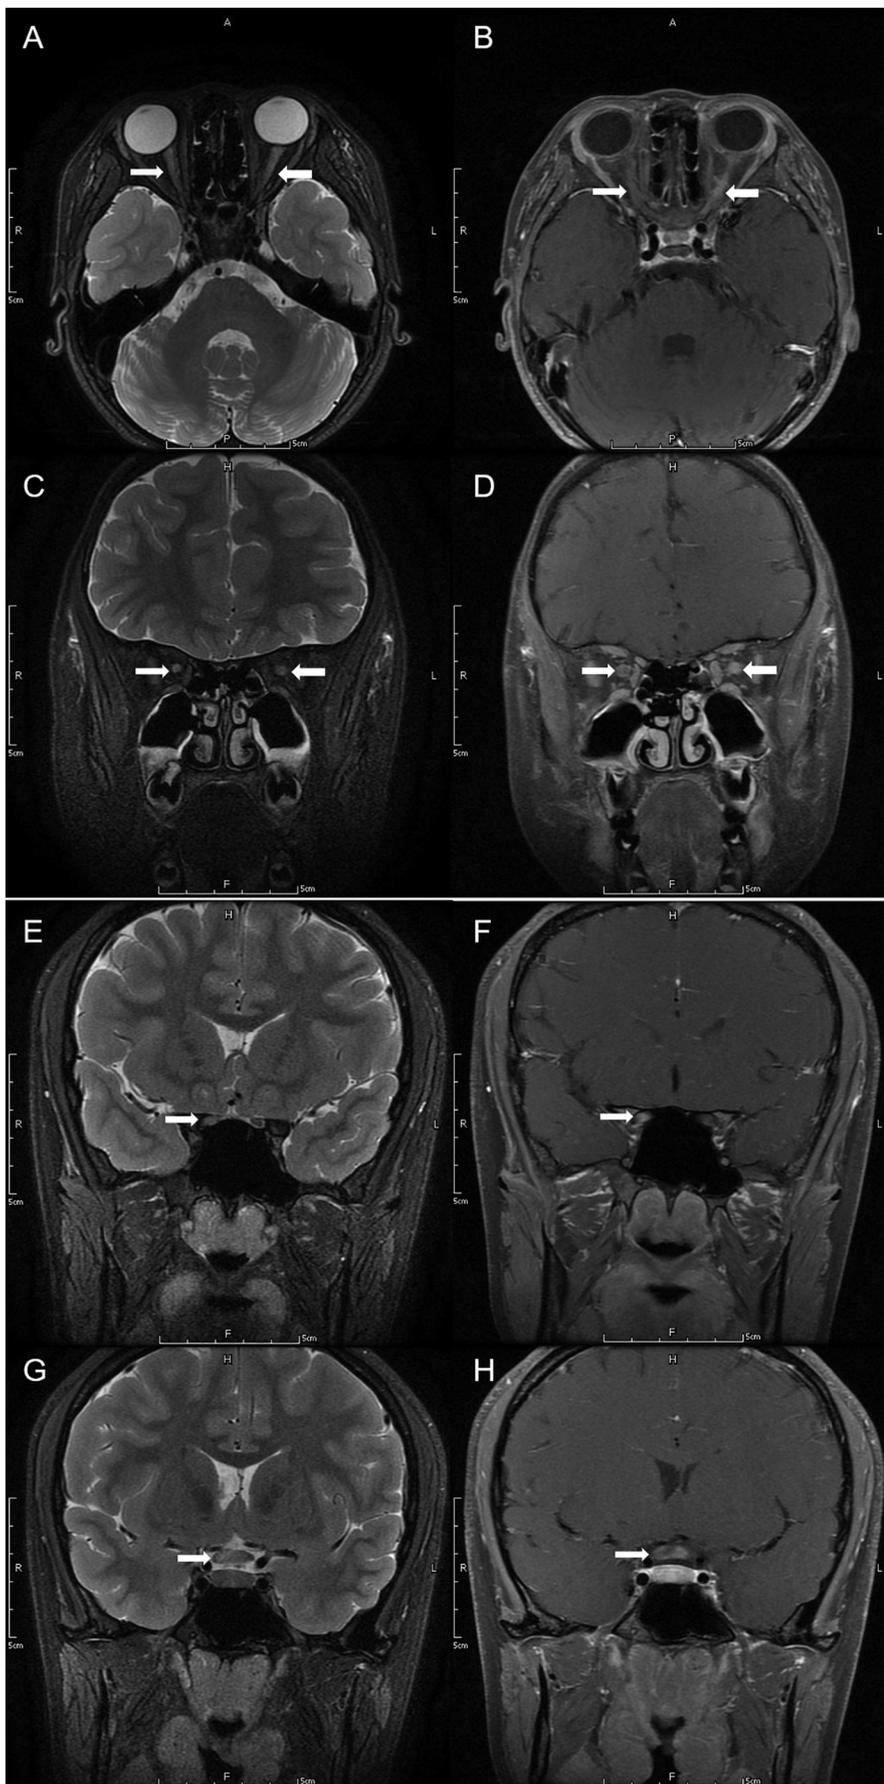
Optic nerve abnormalities detected by MRI in patients with MOG-ON. (A-D) Images from a 5-year-old girl with MOG-ON showing bilateral prominent enhancement of optic nerve and sheath (perineural enhancement), extending along almost the entire nerve (white arrows). (A) Axial T2-weighted Image. (B) T1 postcontrast Image. (C) Coronal T2-weighted Image. (D) T1 postcontrast image. (E-H) Images from a 14-year-old girl with MOG-ON showing longitudinally extensive right optic nerve lesion extending from the chiasm (white arrows). (E) Coronal T2-weighted Image showing extensive T2 high signal in the right canaliculular optic nerve. (F) T1 postcontrast image showing lesion in the right canaliculular optic nerve with marked postcontrast enhancement. (G) Coronal T2 weighted image showing extensive T2 high signal in the chiasm. (H) T1 postcontrast image showing lesion in the chiasm with marked postcontrast enhancement.
